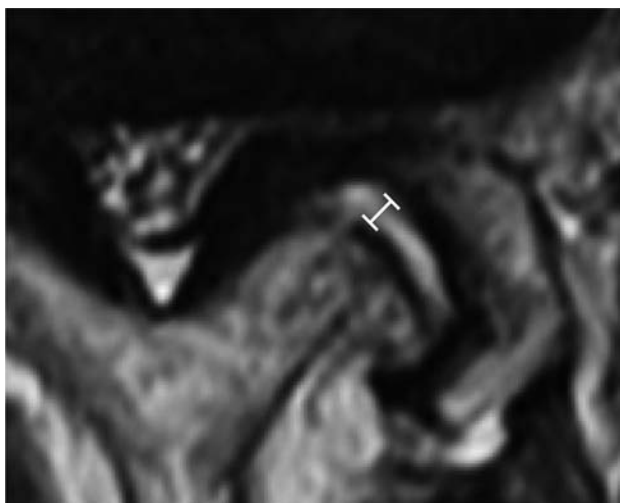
Measurement of the facet fluid width. The facet fluid width is defined as a high-intensity signal area, closely matched to the CSF on axial T2-weighted MR images. The measurements are recorded perpendicular to the joint line, and the largest value is documented as the facet fluid width (white line).
